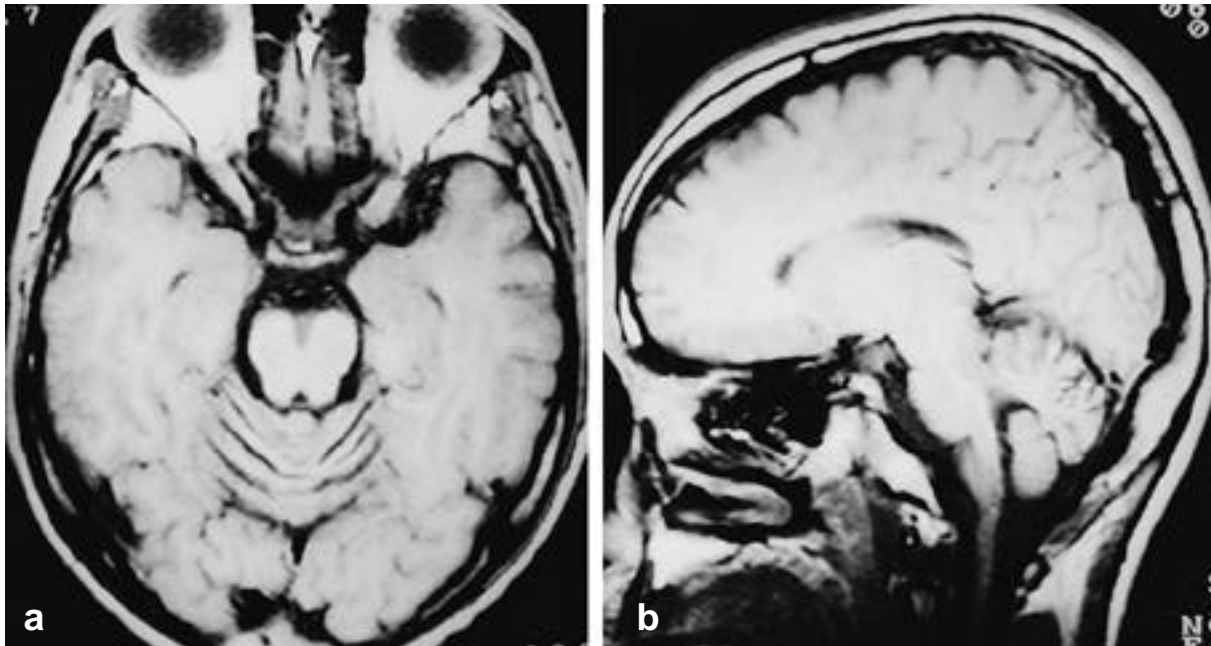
Magnetic resonance images of the patient show mild cerebellar and brain stem atrophy(a. axial view, b. sagittal view).
